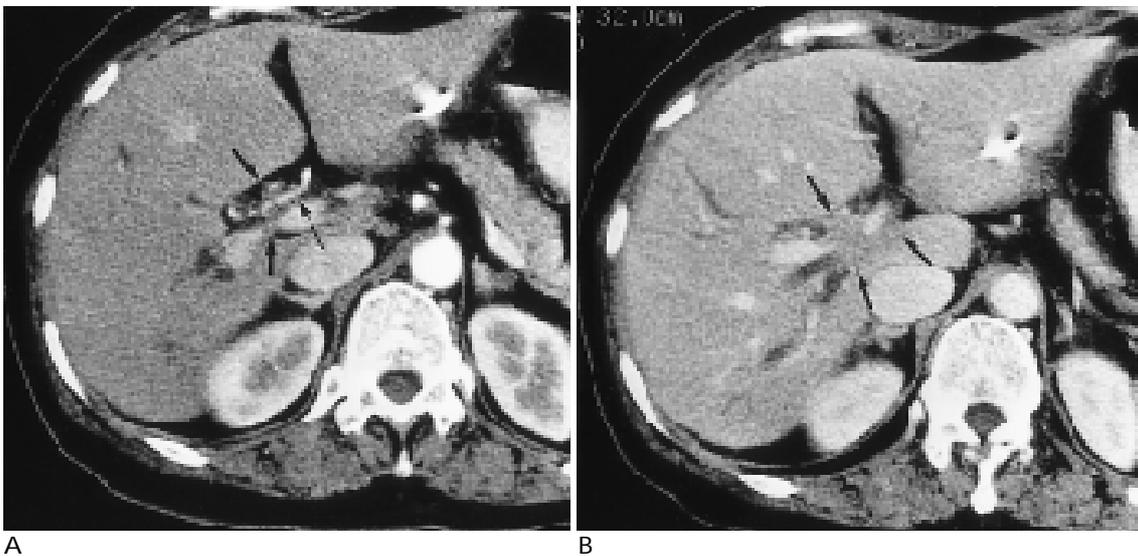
Unresectable tumor correctly diagnosed on the basis of CT and DSA findings.
